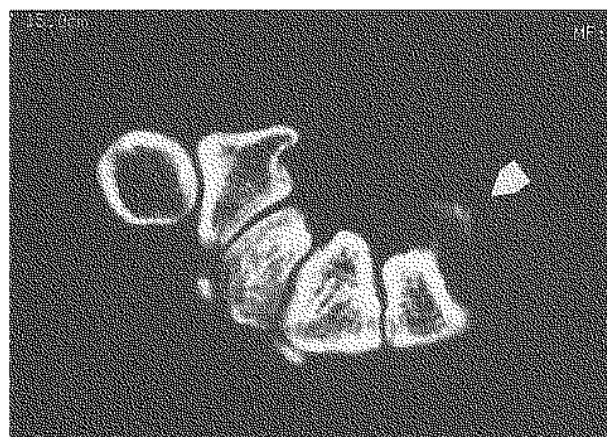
CT-scan of the wrist revealing a density (arrow).
